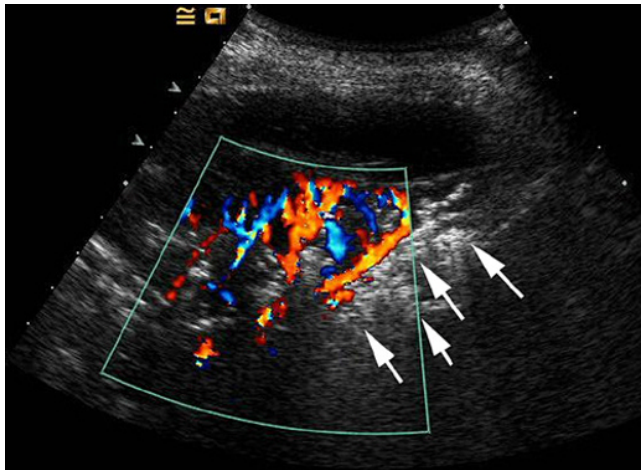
The pneumonia seen in Figure 2.12 shows a profuse pattern of vascularisation on colour Doppler sonography. On gray-scale the 'shredded' transition zone between consolidated and aerated lung (arrows) is seen.
